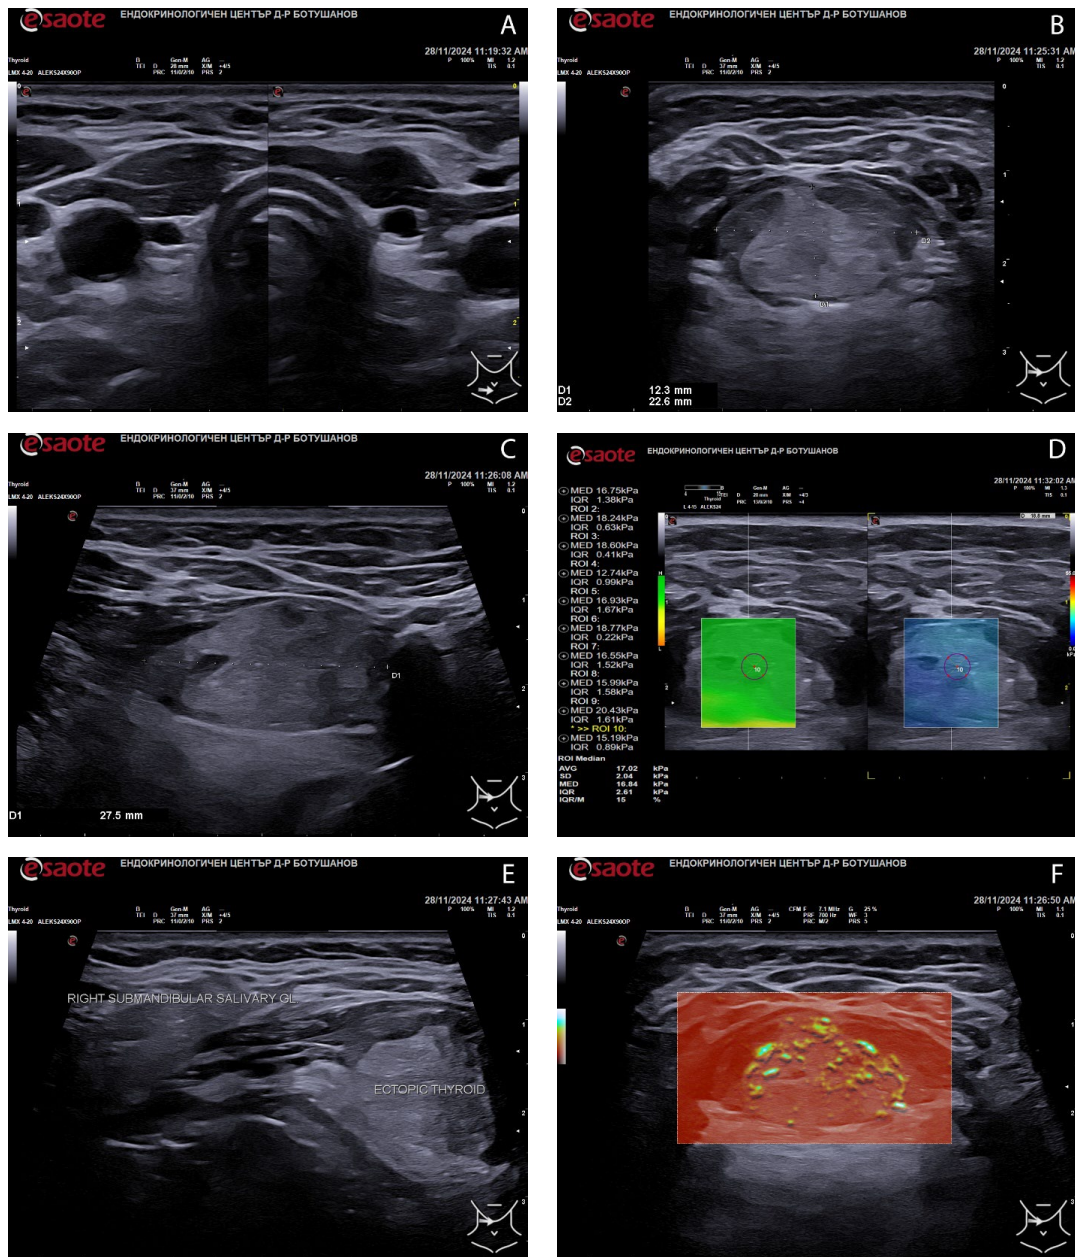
High-resolution ultrasonography of the anterior neck. A. Empty thyroid bed B. & C. Sublingual heteroechogenic mass D. 2D Shear-wave elastography of the sublingual mass E. Relative location of the sublingual mass to the right submandibular salivary gland F. Microvascularization of the sublingual mass
